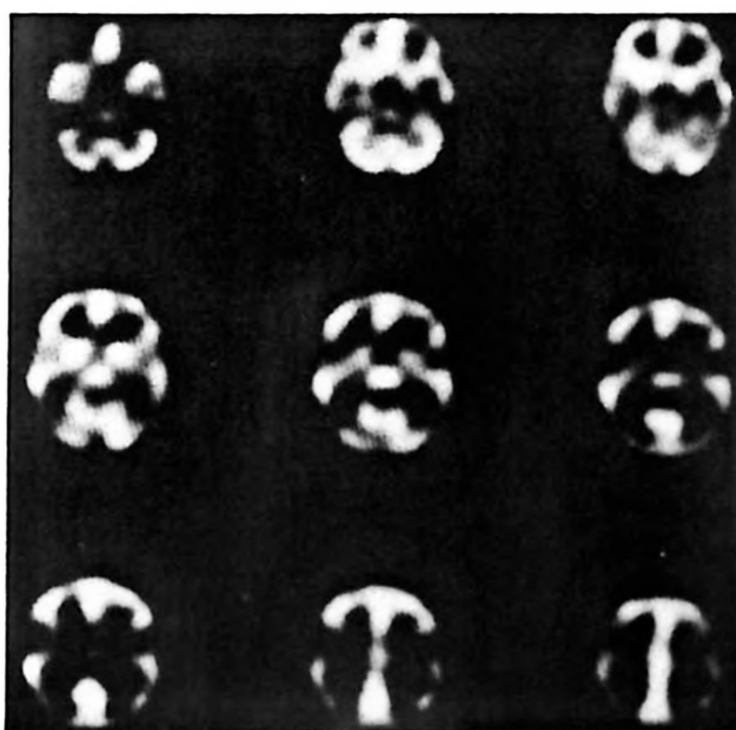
Markedly decreased blood flow in superior temporal and parietal cortices, right occipital cortex, right cerebellum and left frontal cortex in SPECT.
